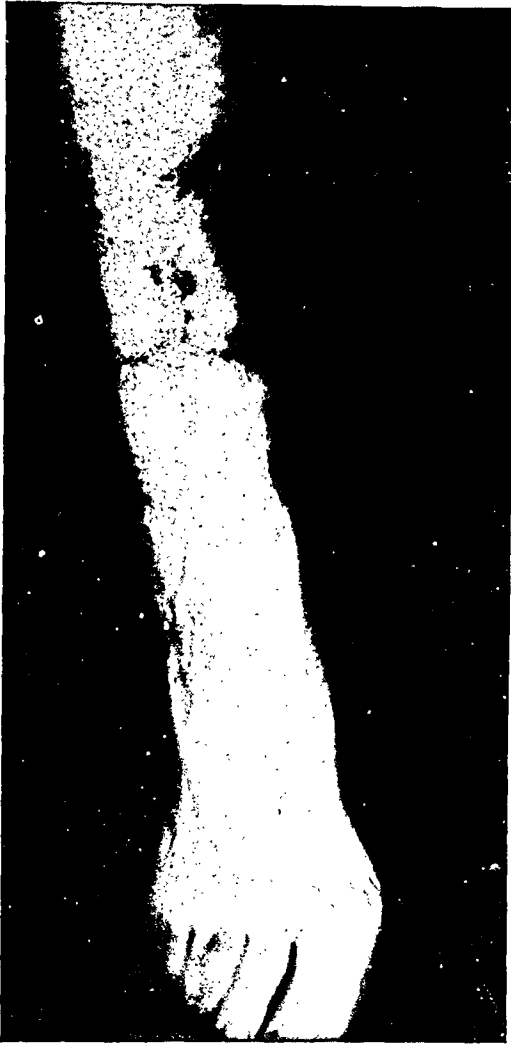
Case No. XI described in the text. The X-rays indicate the fracture a few days after operation, and show the method described in the text, of applying a plaster boot and a cast above the fracture, incorporating in both, the ends of curved metal rods, thereby immobilizing the fracture, and allowing easy access to the wound. The other X-rays and photographs indicate the result at the end of two years.
